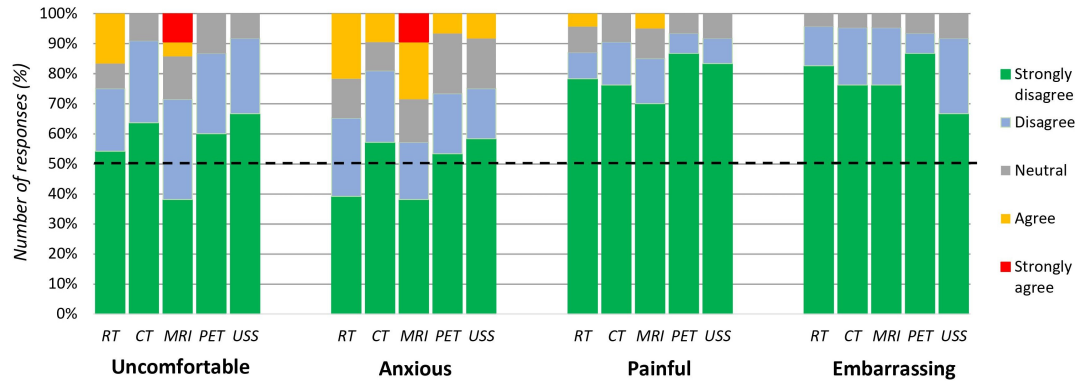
Patients' Experience of Medical Imaging - Stacked bar chart over 5 domains of patient reported experiences of medical imaging in the workup for curative intent radiotherapy treatment for head and neck cancer. RT = radiotherapy planning computed tomography, CT = computed tomography, MRI = magnetic resonance imaging, PET = positron emission tomography and computed tomography scan, USS = ultrasound scan.
